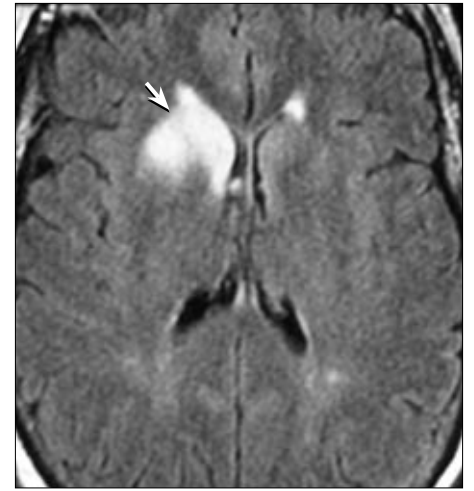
Axial FLAIR MR images demonstrates hyperintense signal of the right putamen and caudate head.
